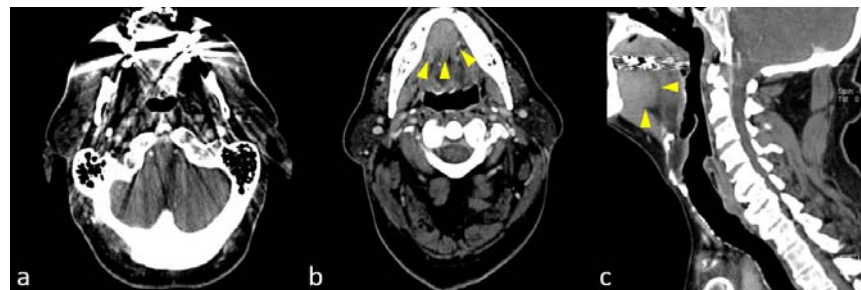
Axial (a & b) and sagittal (c) CT of the neck with contrast shows a lesion in the oral cavity along the ventral surface of the tongue. While clinically obvious by direct visualization of the mucosa, a combination of clinical and radiologic imaging is often necessary for staging. Note in Figure 9a, the oral cavity is obscured by metallic streak artifacts from dental fillings and implants. Without the clinical information of an oral cavity lesion, the artifacts would have made detection of this squamous cell carcinoma more challenging and potentially missed by imaging alone. Figure 9b (caudal to Figure (a) and 9c demarcate the margins of this pathology proven squamous cell carcinoma (yellow arrowheads). Image courtesy of University of Massachusetts Medical School, Department of Radiology.
